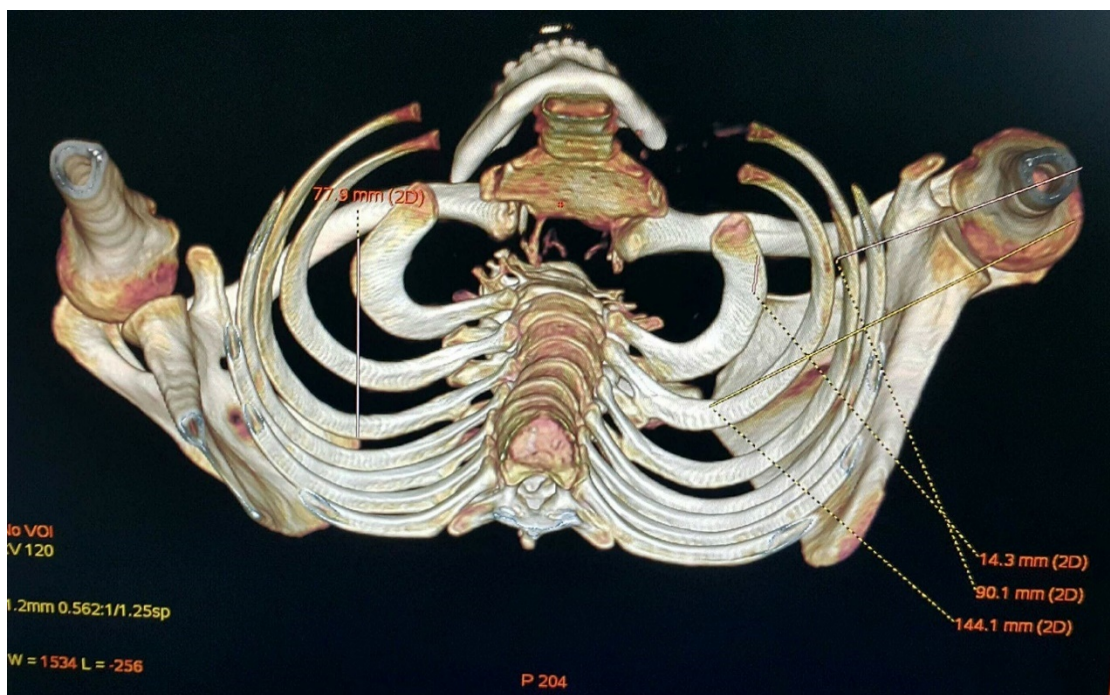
+ Figure 12: Trunk 3D CT scan; Upper view showing narrow space between the left clavicular and the spine of the left scapula: 14mm vs 78mm.
